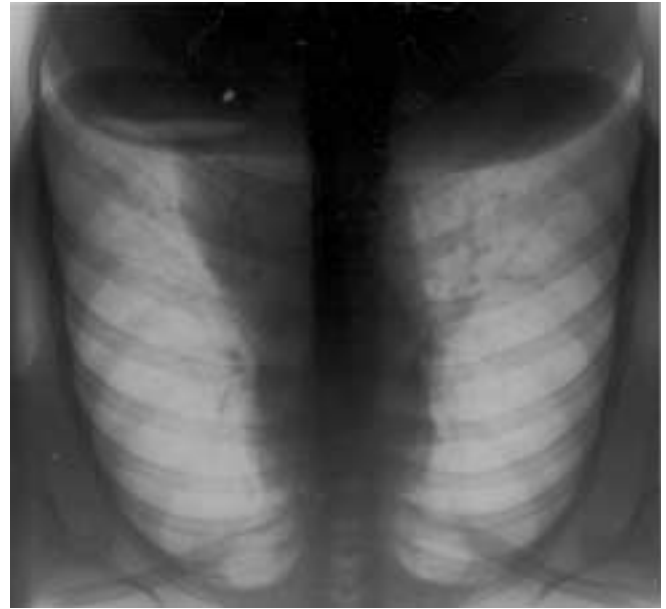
Chest X-ray of a patient with SS showing a mediastinal lymphadenopathy. Lymph node biopsy revealed a high grade diffuse, large B cell lymphoma.
